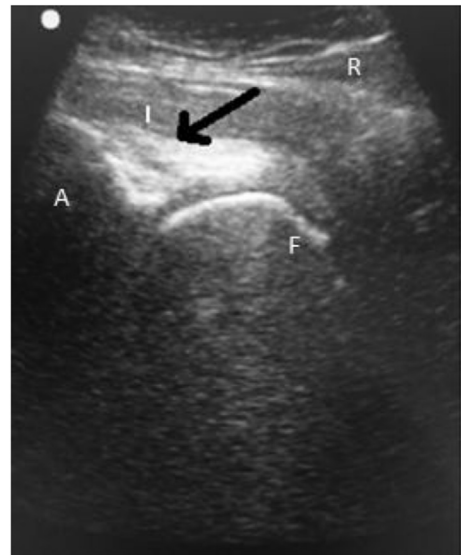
Sonographic image of the L hip depicting an iliopsoas tendon tear with anechoic fluid over the femoral head.
